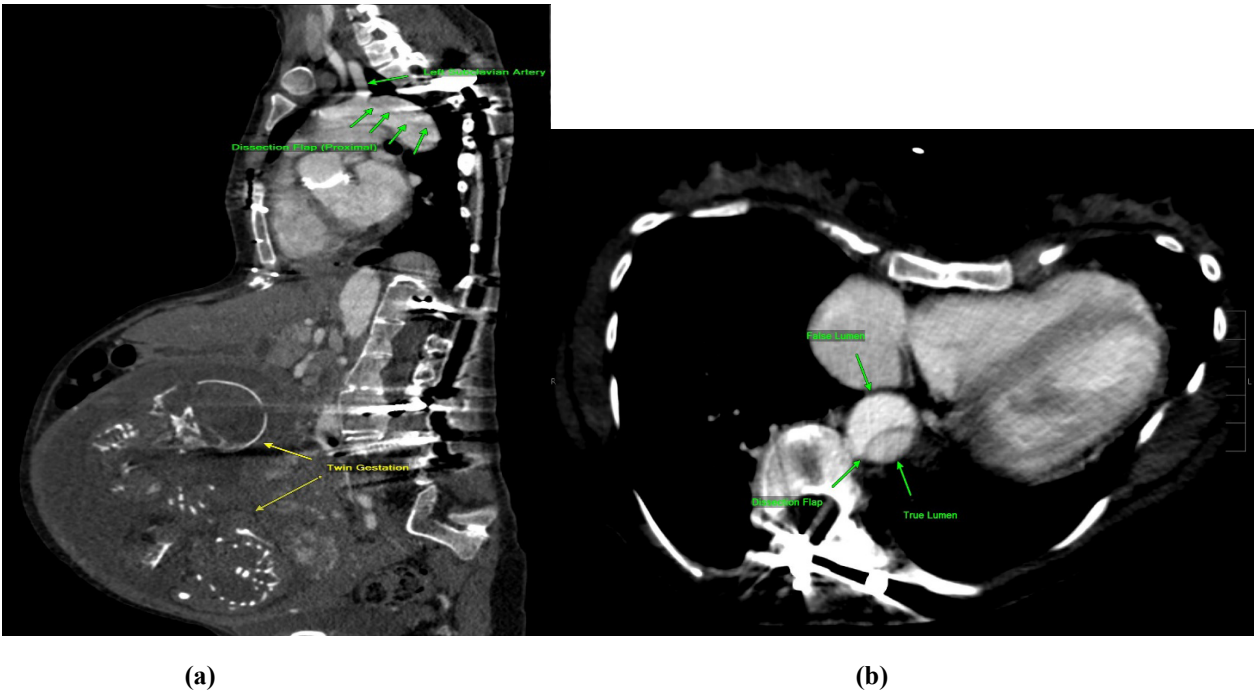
Admission computerized tomography angiogram (CTA) showing a Stanford type B aortic dissection in the a) sagittal plane and b) axial plane.
